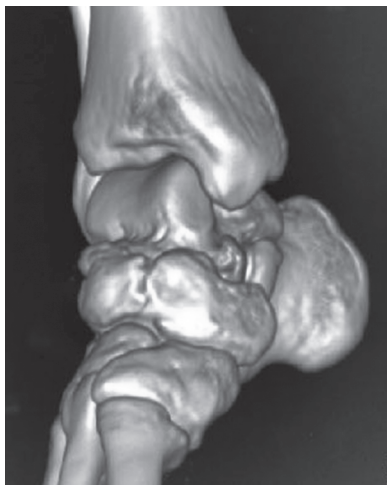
3D CT right foot showing navicular non-union
